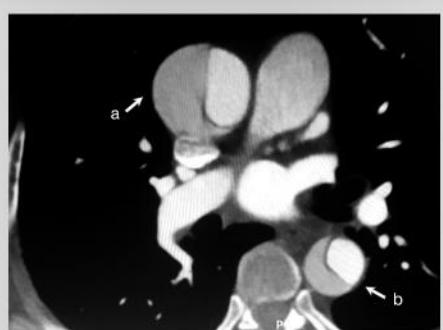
Chest CT angio with contrast showing extended ascending (a) to descending (b) aortic dissection.
